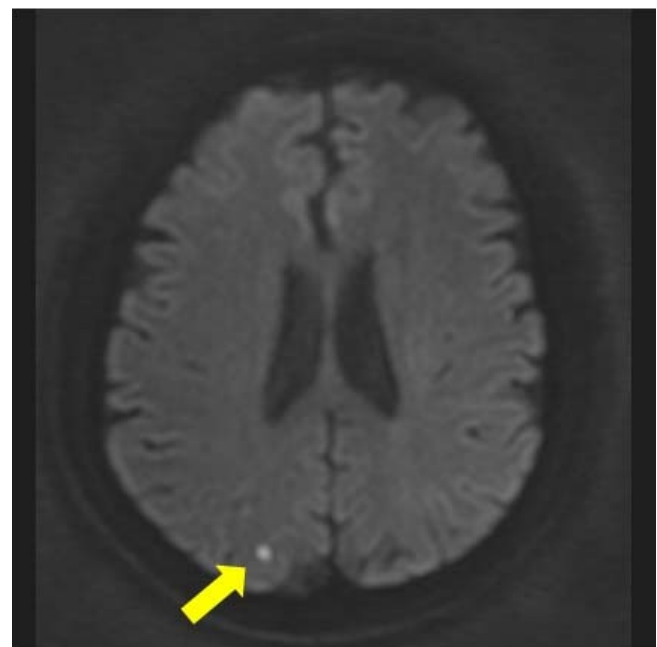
Diffusion-weighted magnetic resonance imaging revealing a high-signal-intensity lesion in the right posterior cerebral artery territory (arrow).
